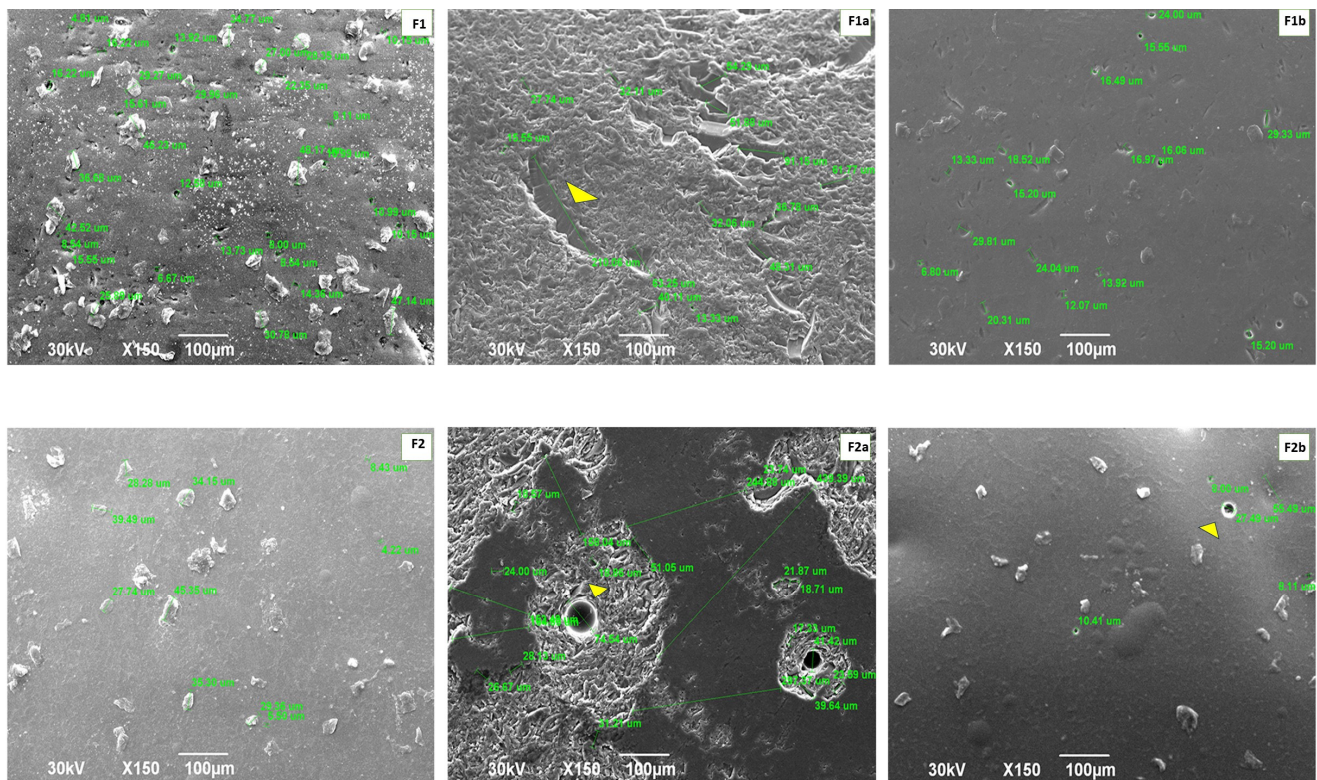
Representative SEM images of the veneered zirconia samples: F1—zirconia veneered and polished samples; F1a—zirconia veneered and polished samples treated with ultrasonic scaling; F1b—zirconia veneered, polished and brushed samples; F2—zirconia veneered and glazed samples; F2a—zirconia veneered and glazed samples treated with ultrasonic scaling and F2b—zirconia veneered, glazed and brushed samples.
